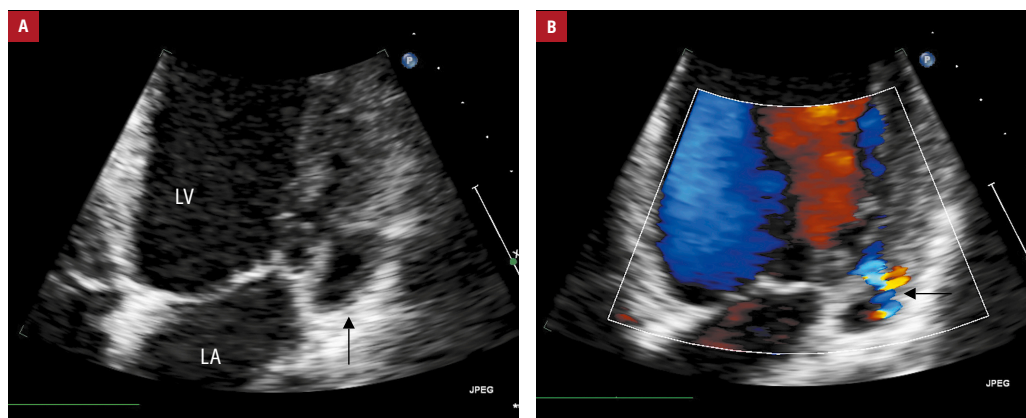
Imaging studies of subepicardial aneurysm: A – transthoracic echocardiography, a zoomed apical 4-chamber view; the arrow indicates the aneurysm; B – systolic blood flow (arrow) on Doppler color flow imaging
